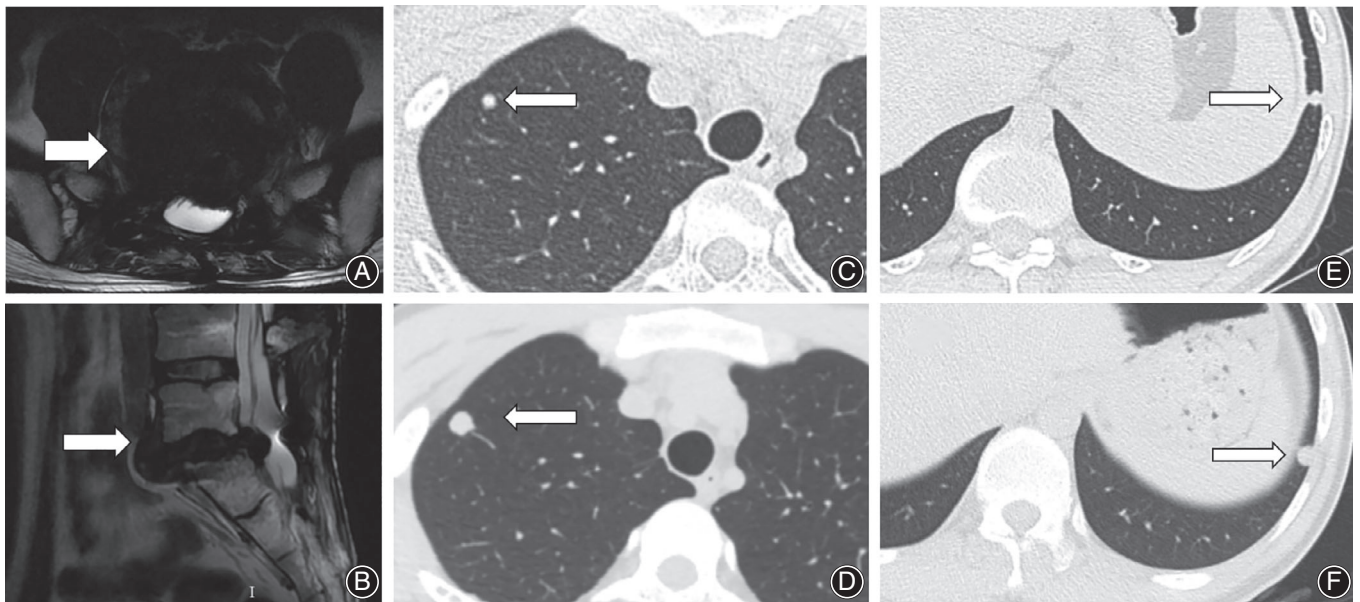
T2-weighted MR image (A, B) at 14-month follow-up, local recurrence was detected, and confirmed by pathology with puncture. Lung metastases (C–F) were discovered after 18 months and progressed during follow-up.
